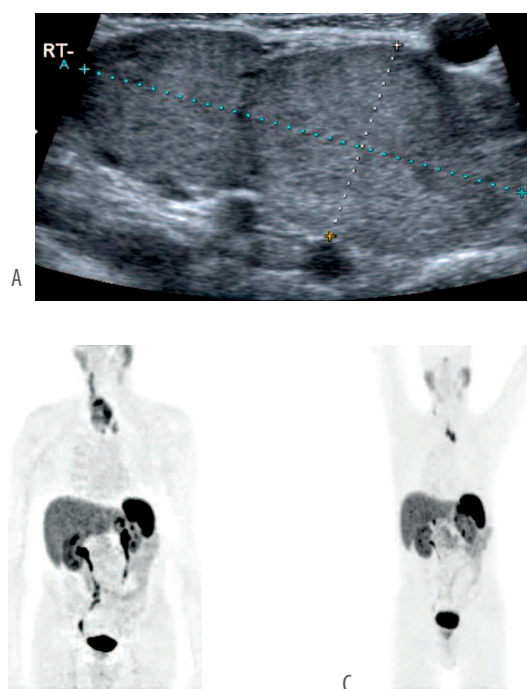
MTC presenting in 2011 with recurrence in cervical nodes on US (A) and further sites of disease in the superior mediastinum on ^{68}Ga -Dotatate PET/CT MIP (B). Post-surgical second recurrence in 2014 in cervical nodes and superior mediastinum on US and CT. ^{68}Ga -Dotatate PET/CT MIP (C) confirming findings on CT and US.
